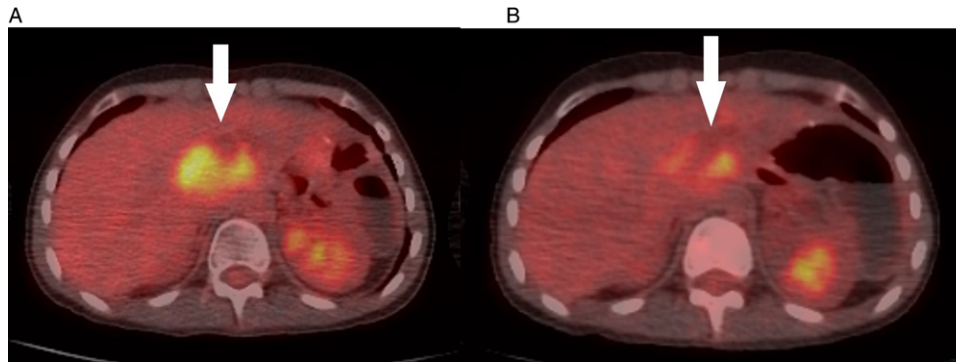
(A) Image from an 18-fluorodeoxyglucose positron emission tomography with computed axial tomography (FDG PET CT) scan of a 13-year-old female demonstrating a hypermetabolic metastatic lesion involving the liver. (B) Follow-up FDG PET CT scan image demonstrating metabolic response following two courses of therapy with vinorelbine, cyclophosphamide, and temsirolimus
